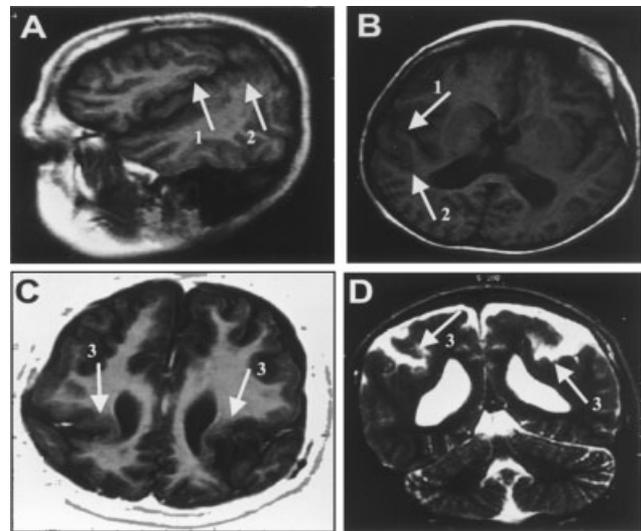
Magnetic resonance images from the proband's cousin. A: Spin-Echo T1-w sagittal sequence. B: Spin-Echo T1-w axial sequence. C: Inversion recovery T2-w axial sequence with video-inversion. D: Spin-Echo T2-w coronal sequence. Note the irregular cortex with bumping surface (arrow 2) around the lateral fissure (arrow 1) bilaterally, with parietal infolding without ependymal involvement (arrow 3). The image suggests polymicrogyria.
